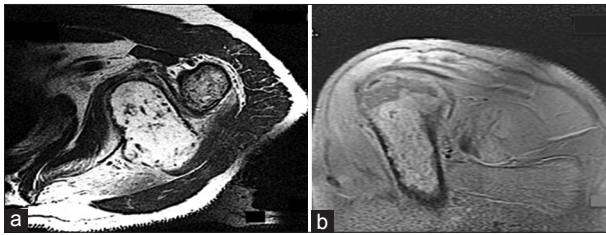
Magnetic resonance imaging. (a) Axial T2 image shows a lytic expansive lesion with multiple flow voids in the scapula. (b) Sagittal PD image showing hyperintense lytic lesion in proximal humerus in the same patient
